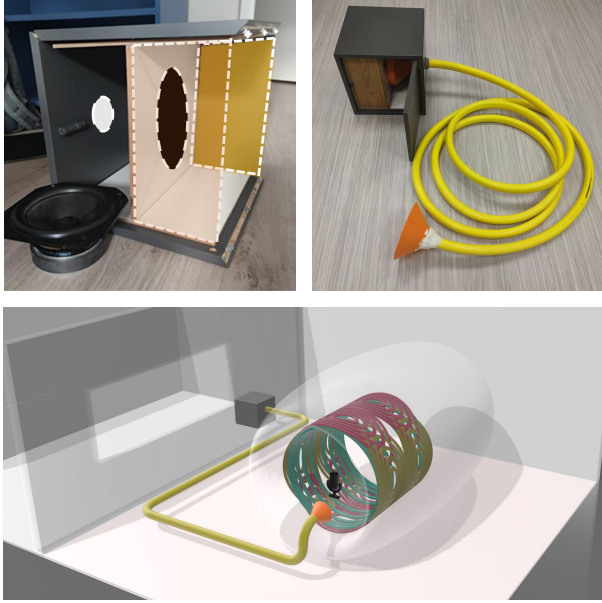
Experimental PNC setup. Top left image shows the speaker box during construction. The box and hose attachment are shown on the top right image. During the experiments, the speaker box is placed in the control room while the other end of the hose is placed inside the MRI bore (bottom).
